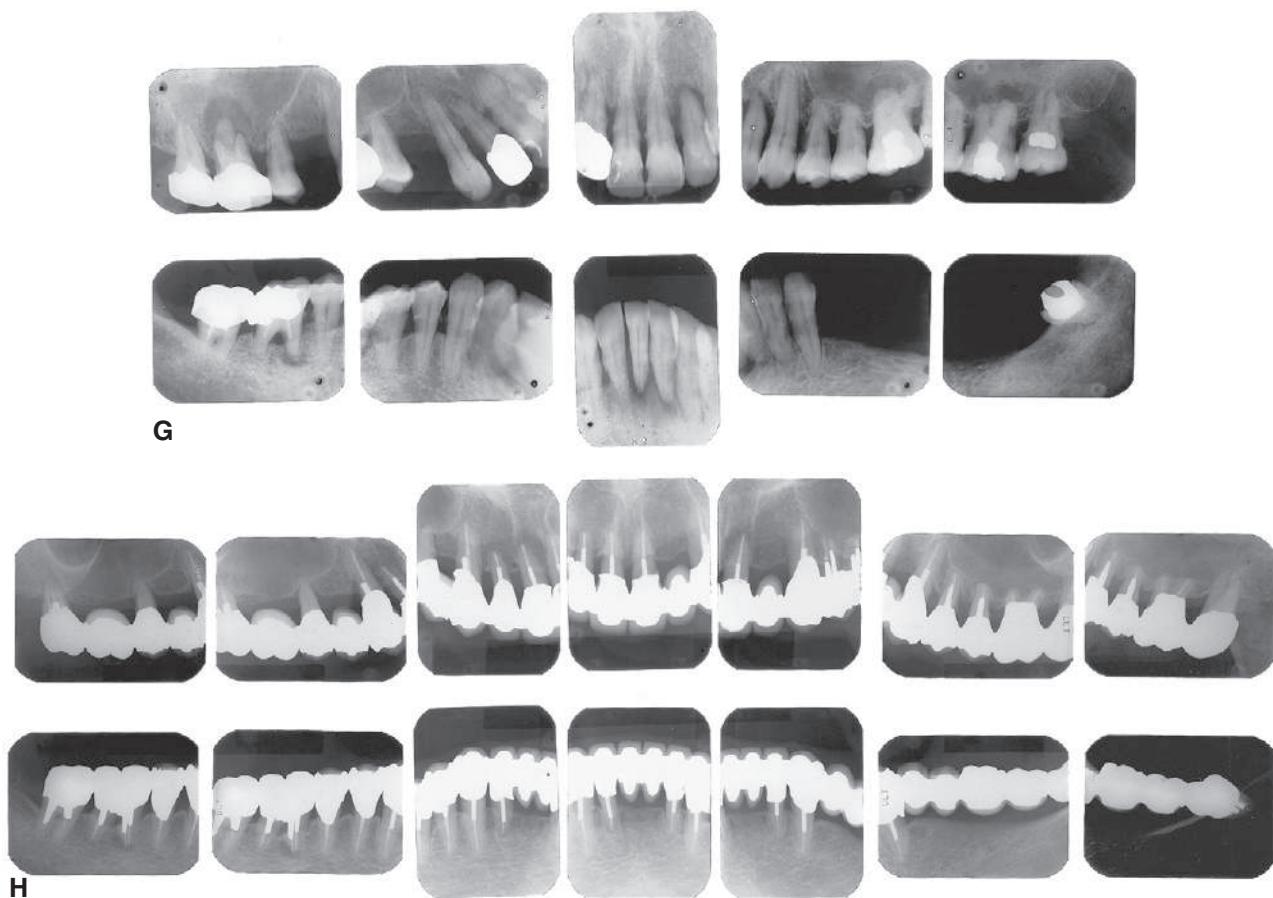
Cont'd (G) Preoperative radiographs. (H) Fourteen-year postoperative radiographs. This patient was referred initially for complete maxillary and mandibular denture fabrication. Before prosthodontic treatment, the periodontal condition was treated. Treatment included a modified Widman flap, performed throughout both arches. A root resection was performed for tooth #14, and tooth #30 was hemisected, which resulted in two premolar-like restorations. Use of the severely tilted tooth #17 as a single abutment to support a very long span posed a substantial risk to the long-term success of this treatment, and the tooth's future loss was anticipated in the design of the prostheses. Another risk was posed by the root structure of tooth #1, with a small, fused root. This tooth was lost after 14 years as a result of a periodontal defect that progressed along a vertical groove in the fused root.
